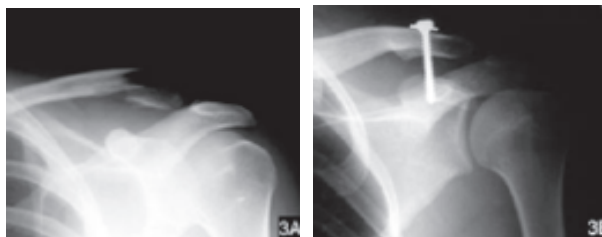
AP radiograph of the left shoulder shows a displaced fracture of the left distal clavicle (A). Satisfactory postoperative radiograph shows union of the fracture 12 weeks after open reduction and internal fixation with a coracoclavicular 6.5-mm cancellous screw (B).
